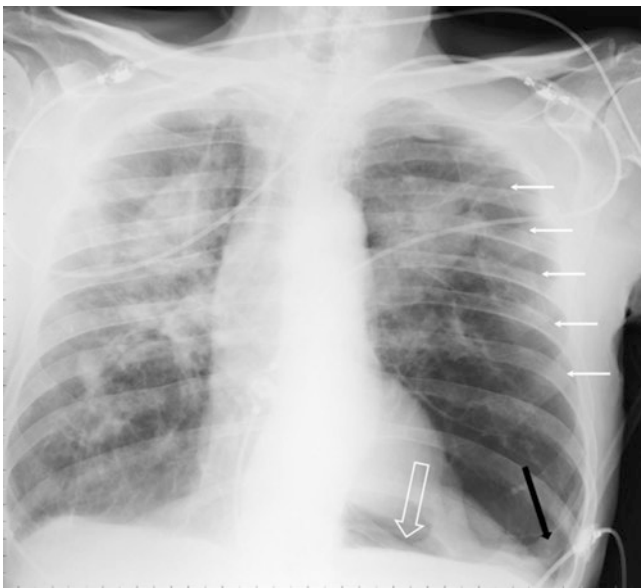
A 78-year-old man with acute left chest pain and previous history of pneumoconiosis. Bedside chest radiograph showing a thin white line near the left chest wall (white arrows), corresponding to the left lung visceral pleura and indicating a pneumothorax. The deep lucency of the left lateral costophrenic angle extending towards the abdomen is an indirect sign of pneumothorax (black arrow). The continuous diaphragmatic sign is also seen as air separating the diaphragm from the heart (white hollow arrow)
